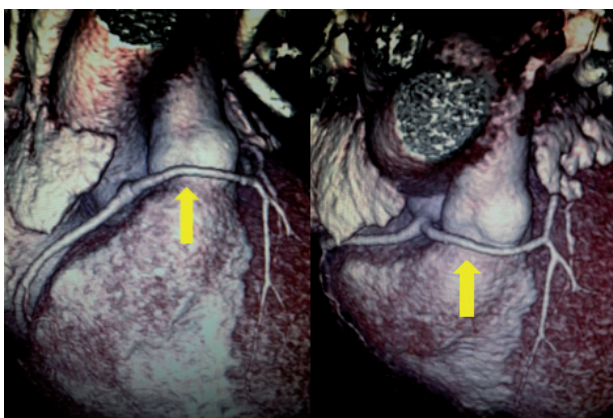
Multislice computed tomography coronary angiography showing long vessel left coronary trunk following a prepulmonary course
